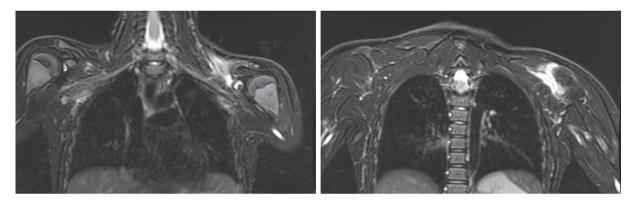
Bilateral shoulder magnetic resonance imaging (MRI), Dixon/T2 water-only images, coronal plane. High signal intensity of the left clavicle and coracoid process of the left scapula (A), of the remaining affected parts of the scapula (B); surrounding soft tissues hyperintensity (A, B)
